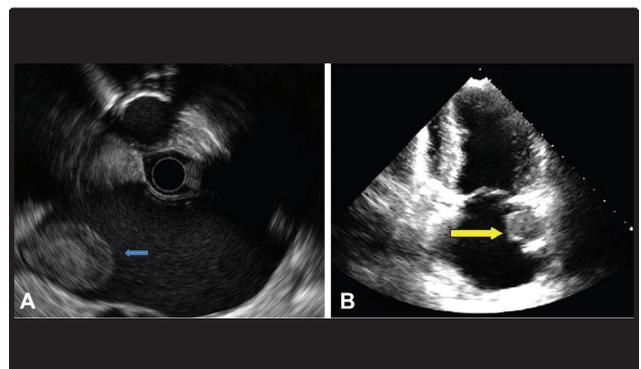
Incidental left atrial thrombus visualized on echoendoscope pull-out while doing EUS for pancreatic cystic lesion. Panel A: EUS image; Panel B: transesophageal echocardiographic (TEE) image.
